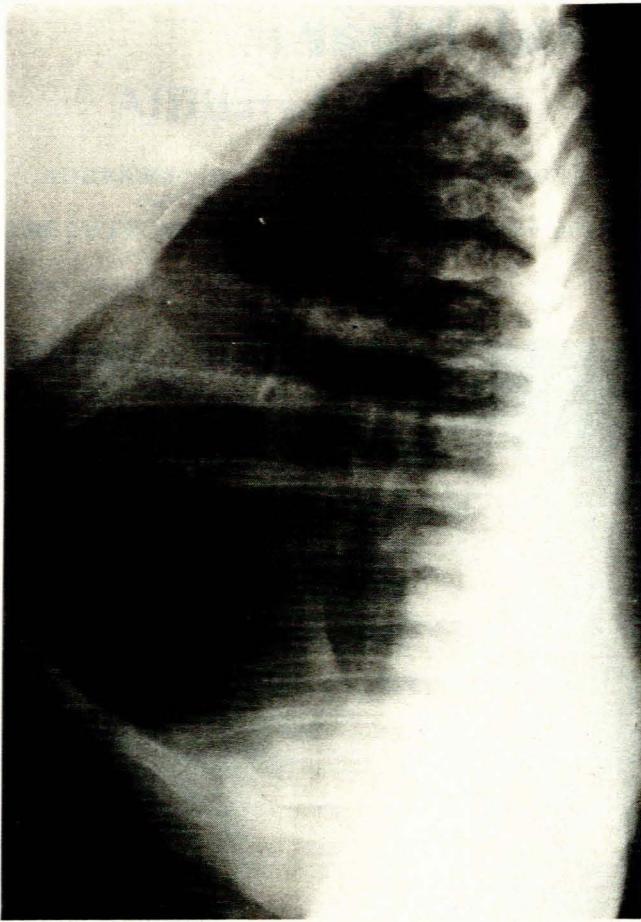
Chest radiograph, lateral view.
